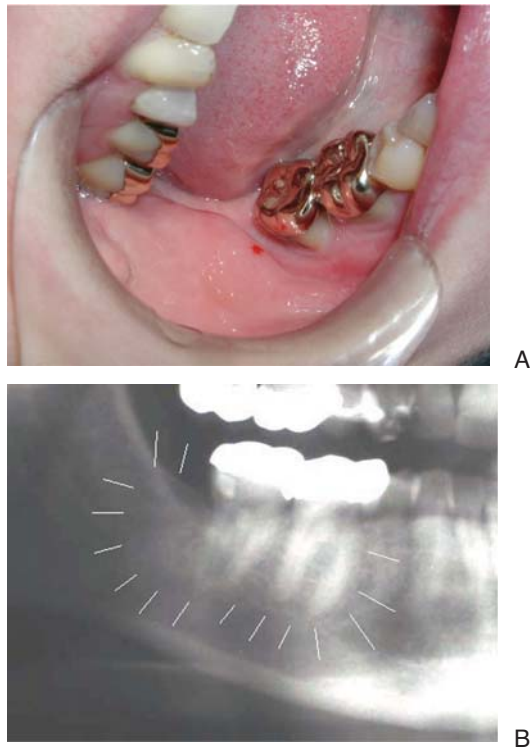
The first image (A) gives the appearance of a healthy jaw condition and X-ray analysis on its own could leave one with an inconclusive or incorrect diagnosis (B). Once diagnosed and surgical treatment is begun, the presence of cavitations becomes obvious.
